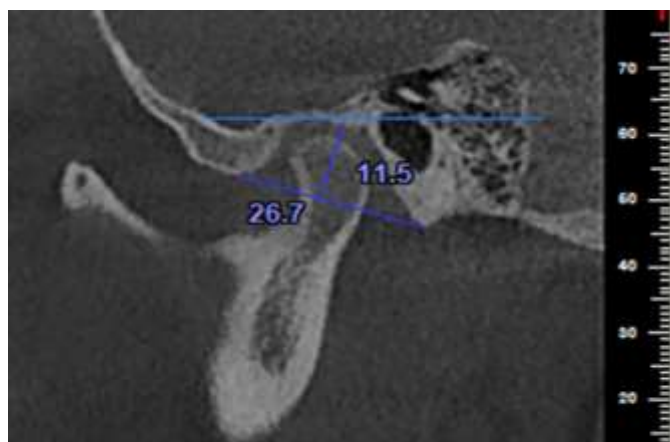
CBCT showed the measurements depth and width of glenoid fossa.
